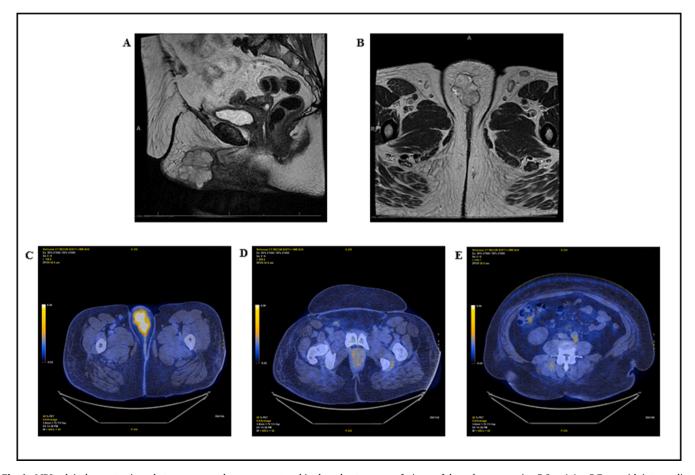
MRI pelvis demonstrating a heterogenous vulvar mass centered in the subcutaneous soft tissue of the vulva, measuring $5.2 \times 4.4 \times 5.7$ cm with intermediate high T2 signal and internal hyperenhancement with restricted diffusion (A and B). PET/CT shows a soft tissue density mass in the mons pubis, measuring 6.7×4.2 cm transverse by 6.5 cm craniocaudal with SUV max 10.3 g/mL (C), a right inguinal lymph node measuring 1.4×1.1 cm with SUV max 4.2 g/mL (D), and *retro*-aortic lymph node measuring 1.6×1.0 cm with SUV max 3.6 g/mL, which was slightly greater than blood pool background (E).
